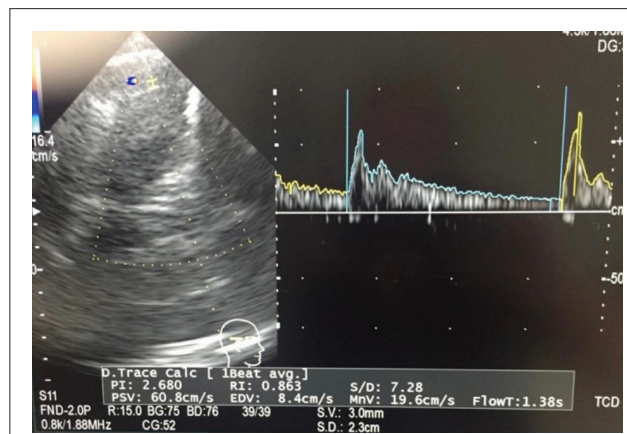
Transcranial Doppler in elevated intracranial pressure.
